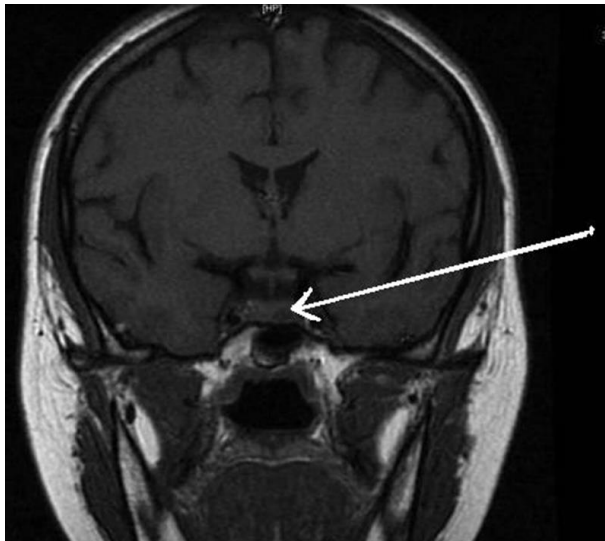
Preoperative contrast-enhanced pituitary MRI of a 21-year-old woman diagnosed with Cushing's disease: microadenoma measuring 4/6.5mm. Coronal plane.
